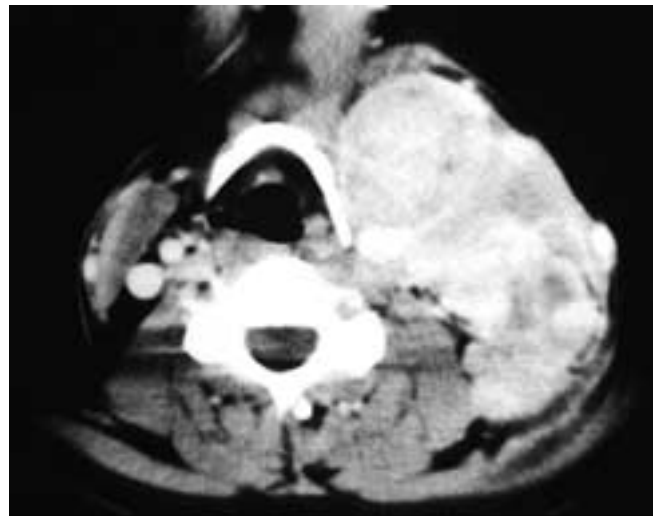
Axial contrast-enhanced CT scan shows multiple grossly enlarged, enhancing left level I, II, and III nodes. There is minimal involvement of the adjacent fat planes in this patient with large cell lymphoma.
